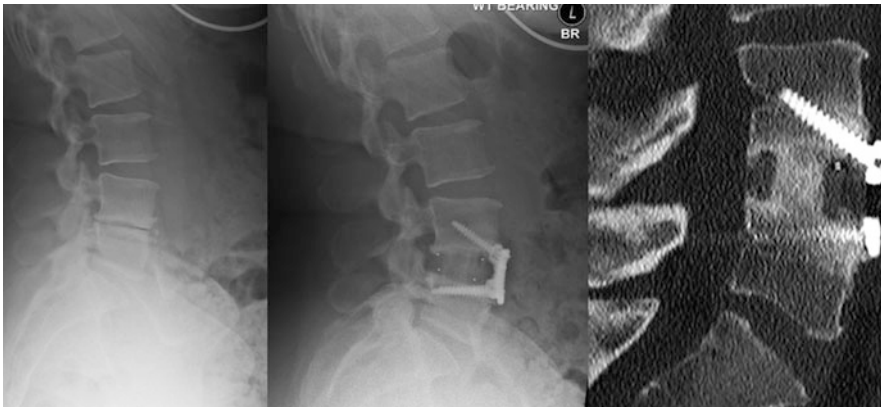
An example of indirect neuroforaminal decompression obtained by restoring the disc height and a CT scan showing solid fusion at 4 months
